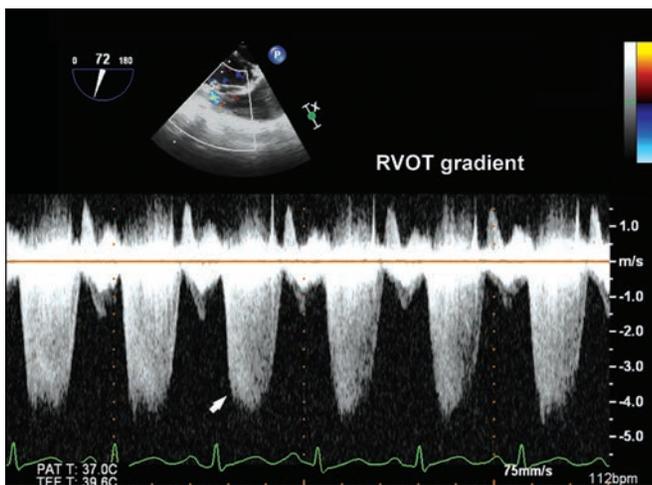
Continuous wave Doppler across the right ventricular outflow tract with a systolic gradient of 81 mm Hg (arrow).
